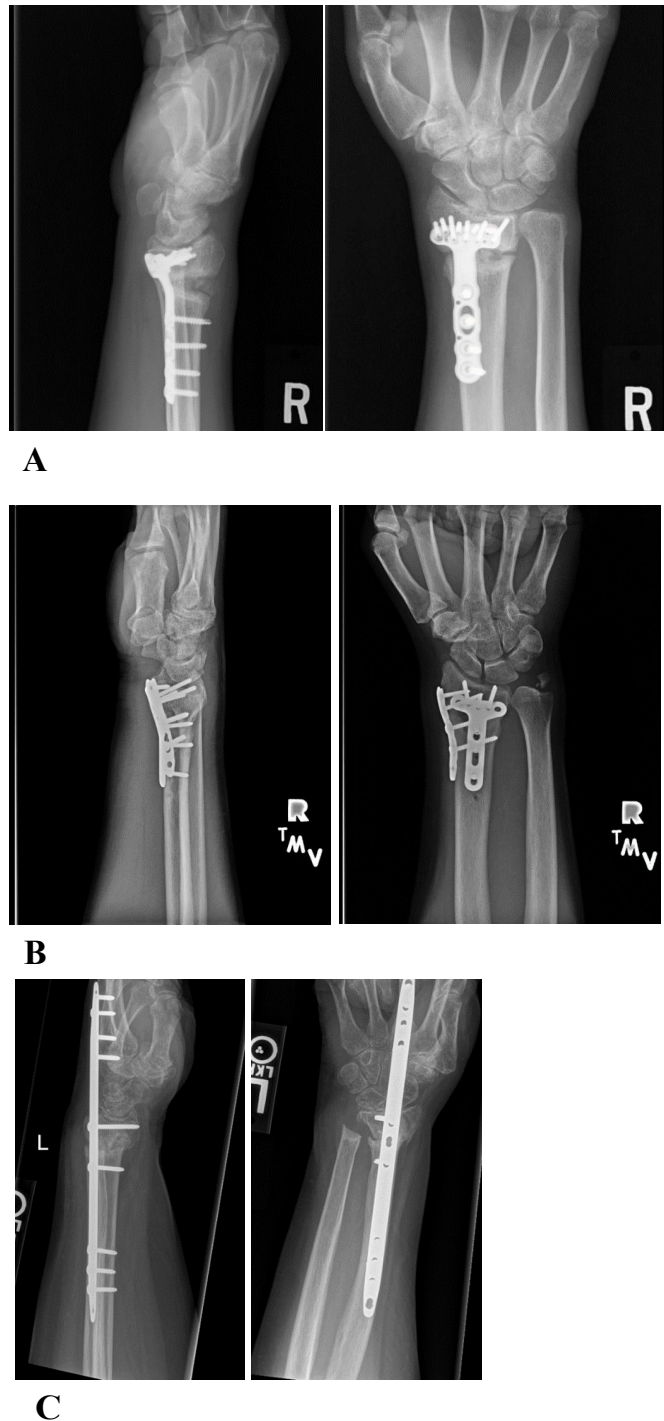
Radiographs of plate constructs. A. Volar plate; B. Multiple plates; C. Dorsal spanning plate
